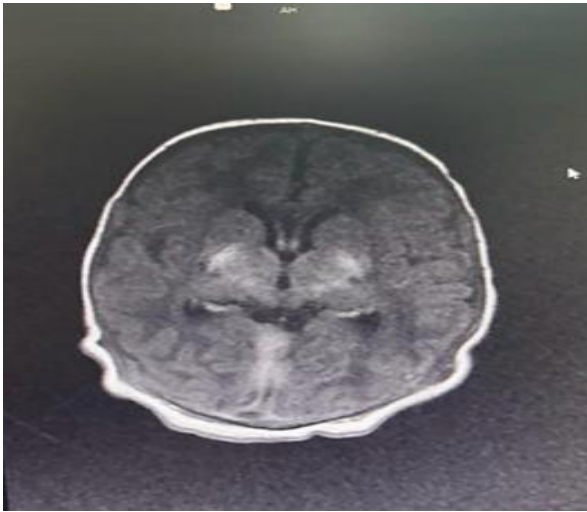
Brain MRI showing T1 hyperintensity involving the bilateral basal ganglia and thalami. Mild subdural haemorrhage was also documented, with no diffusion restriction.
